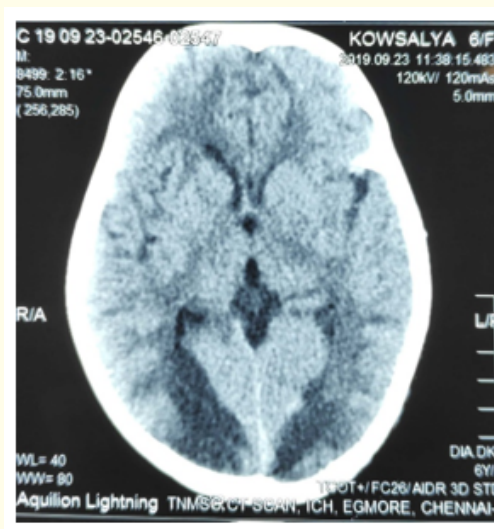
CT Brain showing bilateral fronto-parieto-occipital white matter hypodensity.
